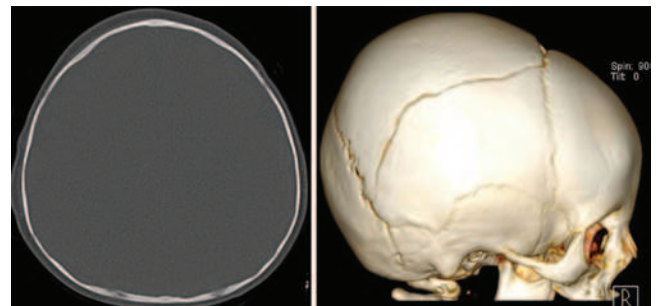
Images obtained of a 23-month-old girl who presented after a motor vehicle accident in which she was a restrained back-seat passenger in a car seat, which was forward-facing. The 2D CT scan shows no fracture line (left), whereas the 3D CT scan (right) reveals bilateral nondisplaced fractures of parietal bones extending to the coronal suture (arrows). Figure is available in color online only.
